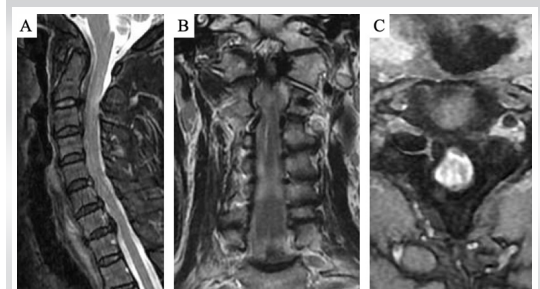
Pre-operative T2-weighted magnetic resonance imaging. (a) Mid-sagittal, (b) coronal, and (c) axial.
